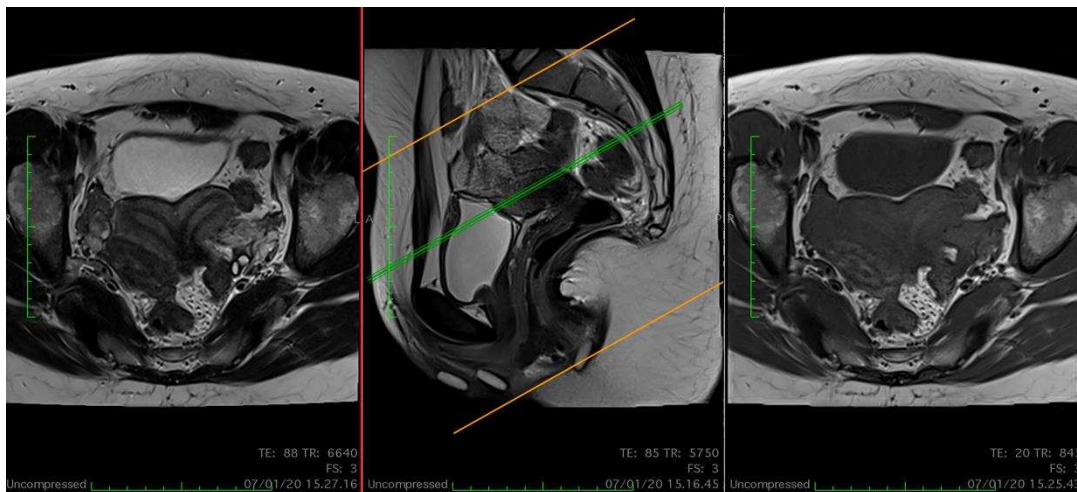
T2WI MRI of coronal, sagittal, axial pelvis, Mrs V, 35 years showing partial uterine bicornu
